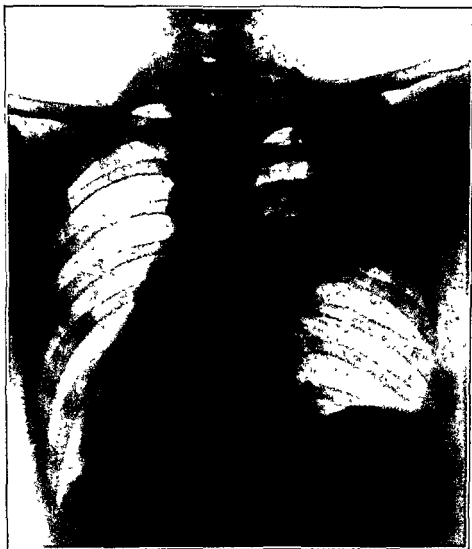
Fig. 27 is an x-ray of an exudative productive form of pulmonary tuberculosis (Case No. 1, page 71) Figs. 28, 29, 30, 31 and 32 demonstrate the slow and irregular mode of resolution of this type of tuberculosis.
